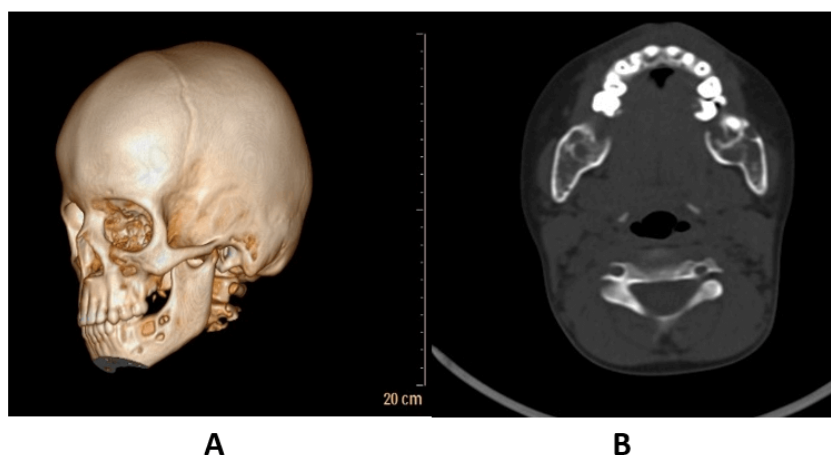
A, 3D reconstruction; B, axial CT scan shows the regressive course of the lesion 8 months post imatinib treatment.
